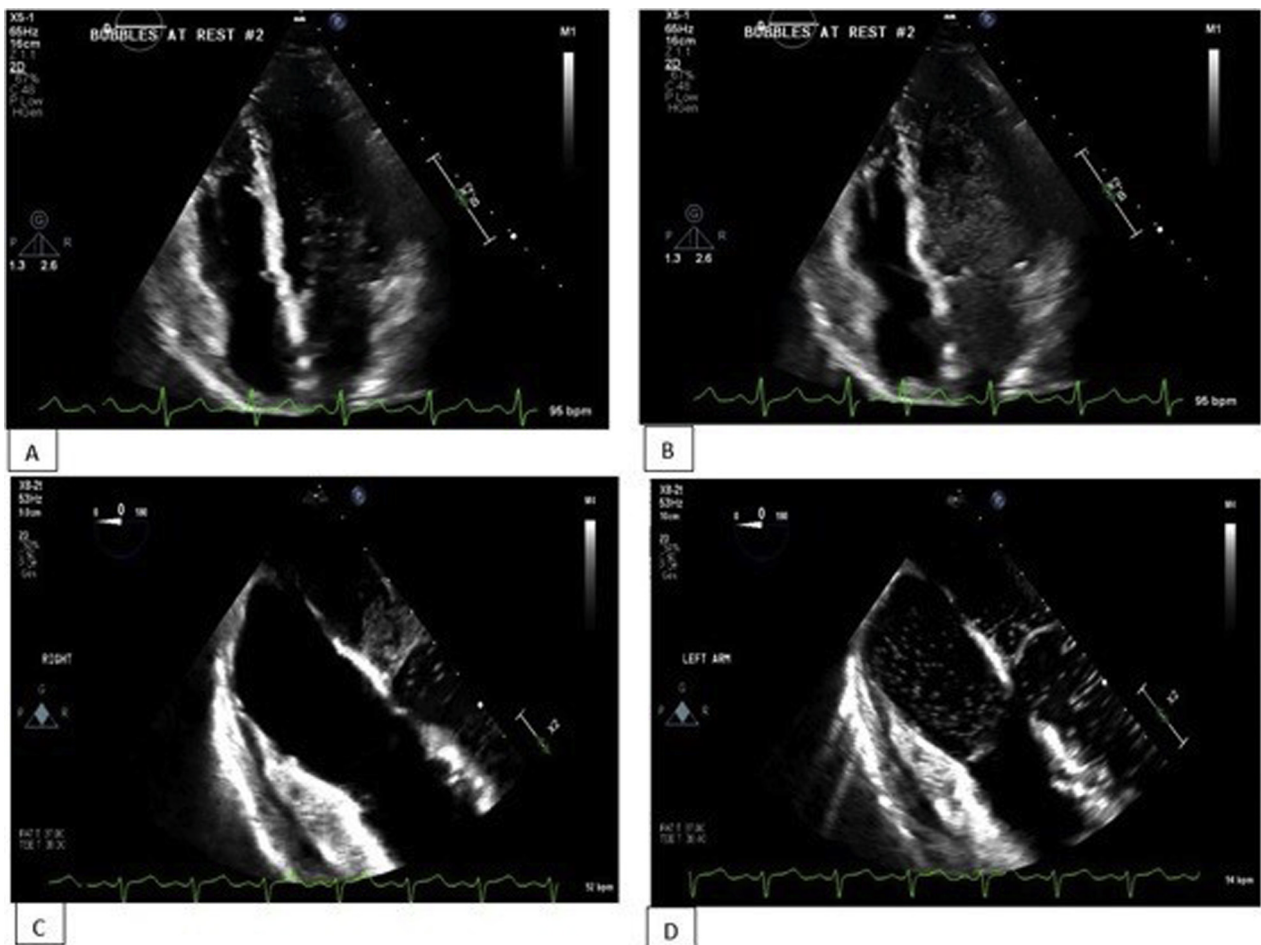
Transthoracic echocardiography, four-chamber view, showing bubbles appearing in the left atrium and then the left ventricle, with none on the right side of the heart, when agitated saline was injected from the right arm (A, B). Transesophageal echocardiography similarly showed bubbles in the left atrium when contrast was injected from the right arm (C). The same view demonstrates bubbles in the right atrium when contrast was injected in the left arm (D).
